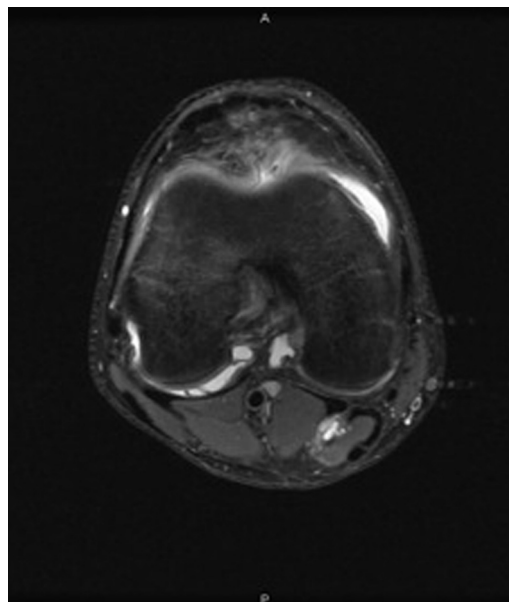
Asymmetric appearance of the posterior joint capsule due to medial contracture (MRI, axial view).
